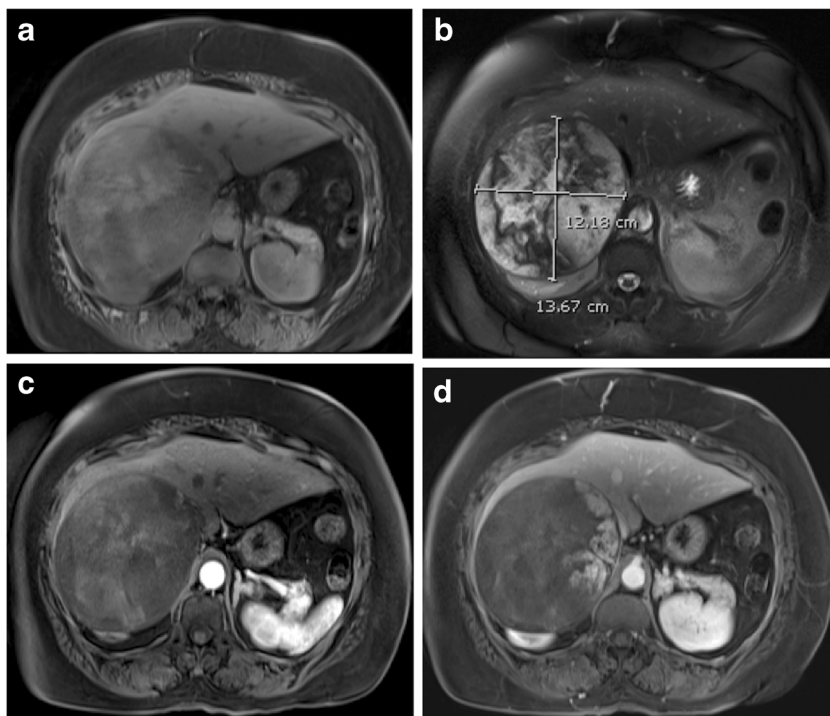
Angiosarcoma in a 71-year-old female. Transverse T1-weighted fat-suppressed three-dimensional (3D) gradient echo (GRE) (a), T2-weighted fat-suppressed single-shot echo train spin echo (b), post-gadolinium fat-suppressed T1-weighted late hepatic arterial phase (c) and equilibrium phase 3D GRE (d) images. Pre-contrast images (a, b) show heterogeneous round large mass with mixed signal, which is suggestive of haemorrhage. Late arterial phase image (c) shows minimal peripheral enhancement and portal venous phase image (d) shows centripetal progressive nodular enhancement. The centripetal progressive enhancement mimics the appearance of a haemangioma
